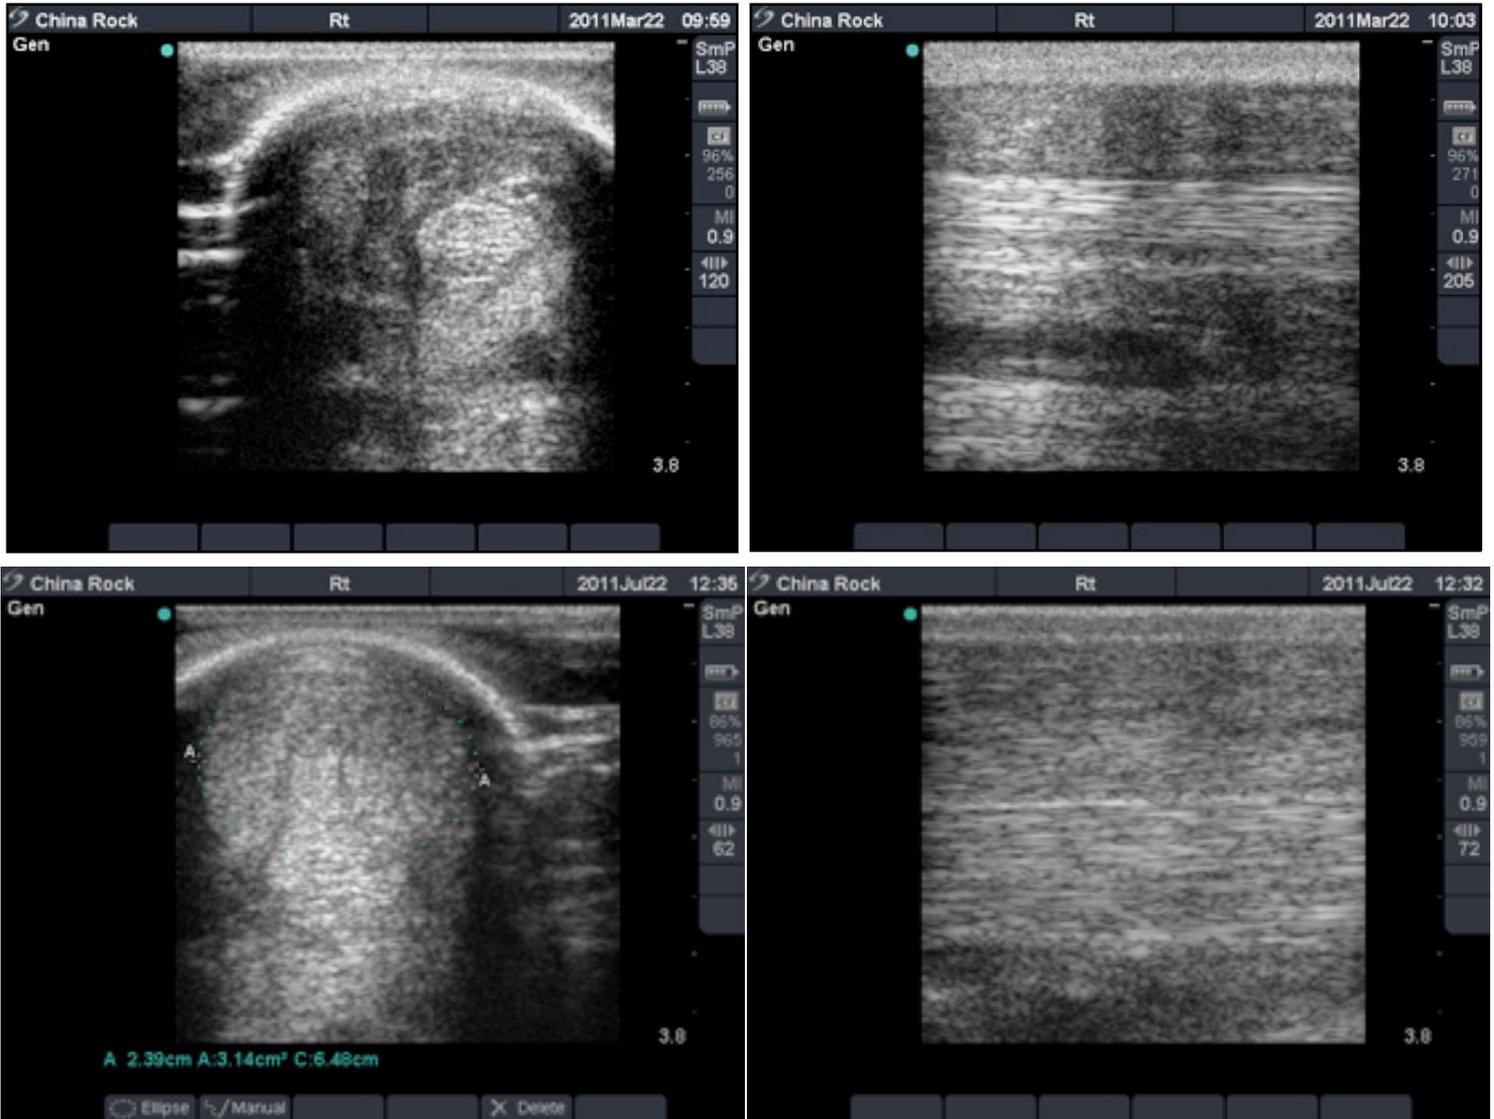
From top left, the original examination 22nd March 2011 to the final ultrasound examination July 22nd 2011 highlighting the improvement in the tendons structure.
